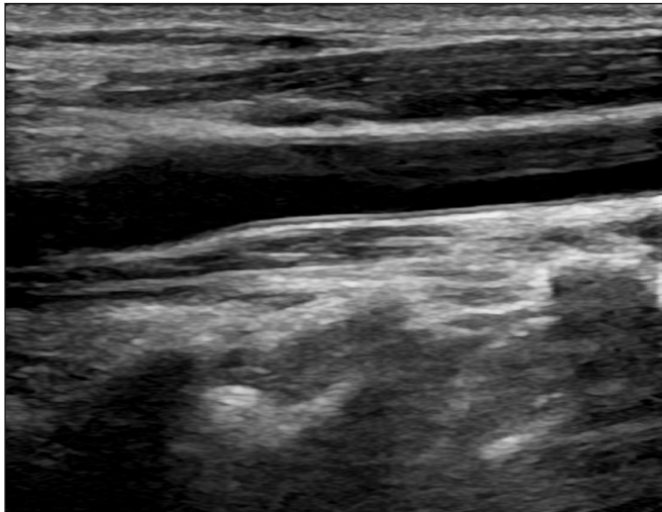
The figure shows the evaluation of the right common carotid artery with gray scale ultrasound.
